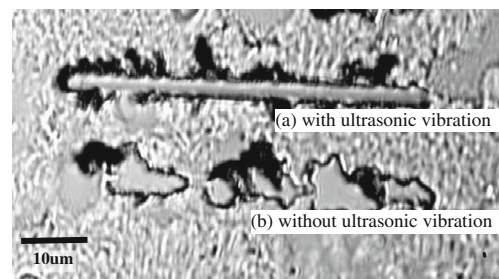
Tissue micro-dissection with and without ultrasonic vibration
